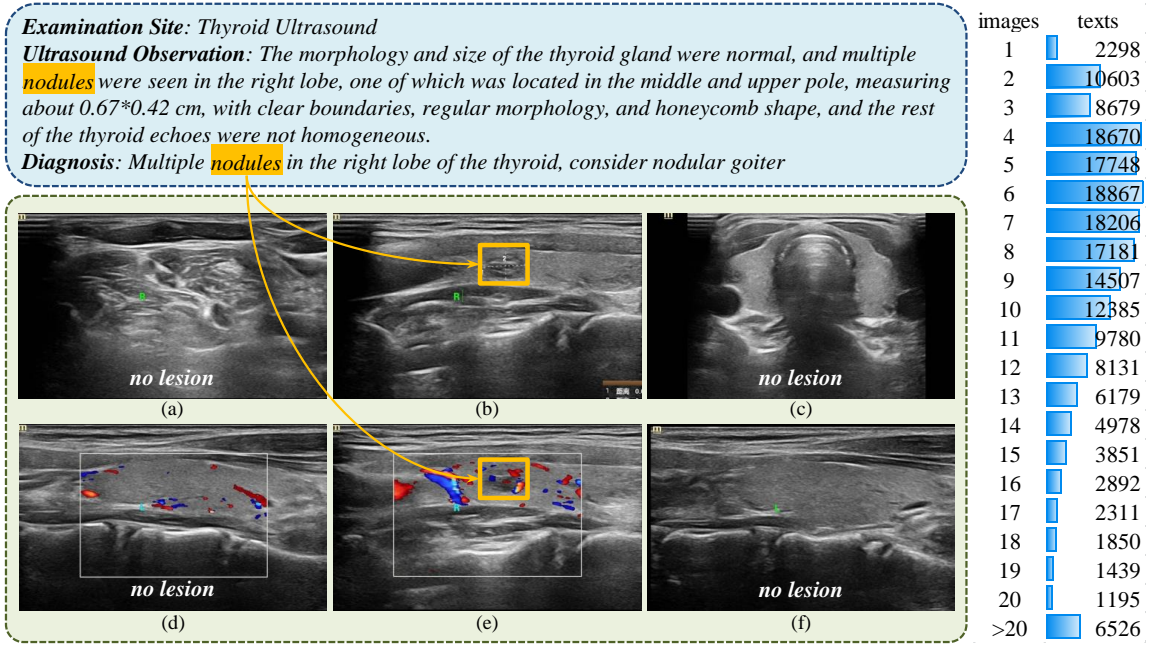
Detailed Description of Data Redundancy: (Left) An example of thyroid ultrasound from the same scanning examination of the same person. (Right) Statistics on the number of images matched by a single text instance.
